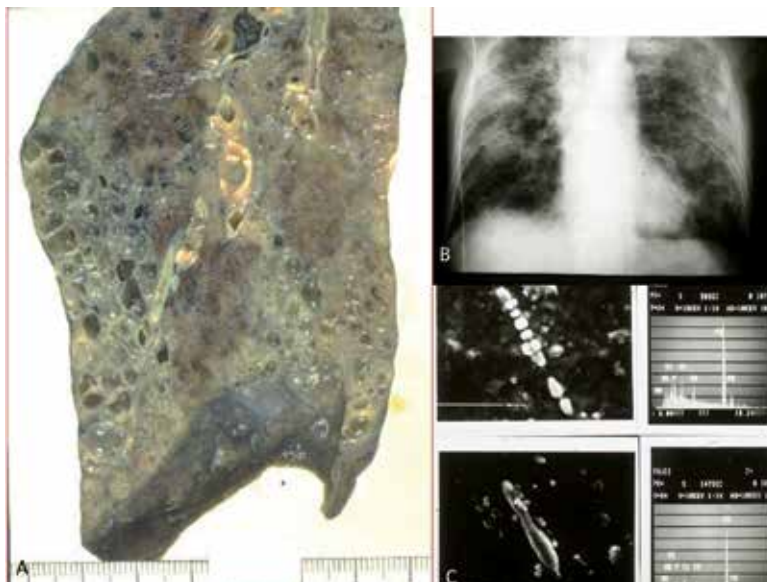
Radiological and pathological features of an asbestos exposed worker that does not fulfill asbestosis criteria. A case of pulmonary fibrosis in a 73-year-old male asbestos worker who visited a hospital because of acutely progressive dyspnea. Clinically, this case was diagnosed as acute exacerbation of IPF. Usual interstitial pneumonia (UIP)-type fibrosis and pleural and pericardial plaques were found at autopsy. He had worked several months at a shipyard 40 years ago during war time. The number of asbestos bodies (ABs) was 740/g dry lung. Macroscopic features are typical for UIP with clear subpleural honeycombing in the right lower lobe, and no pleural fibrosis or adhesions were found. Plain chest X-ray showed diffuse infiltrative pulmonary shadows bilaterally. Typical (upper left) and atypical ABs (lower left) were found, but these were almost all composed of chrysotile as confirmed by energy-dispersive X-ray analysis (right).
